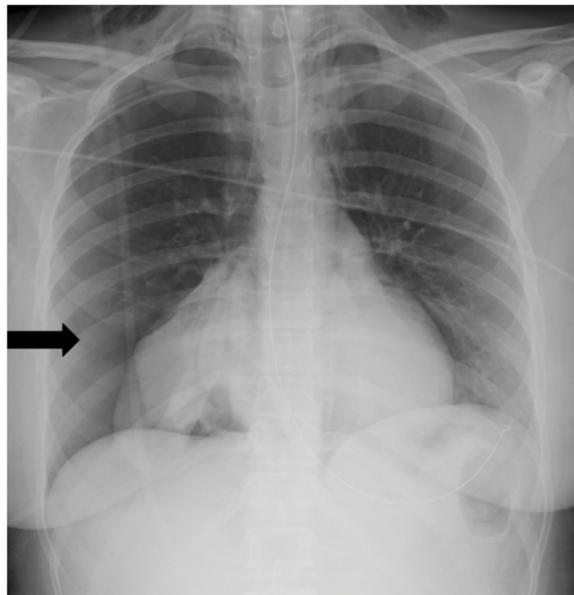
Chest X-ray 3 hours after extubation (16:15 PM); right pneumothorax and atelectasis of the right lower lobe and subcutaneous emphysema of the neck, right axilla, and upper mediastinum.
